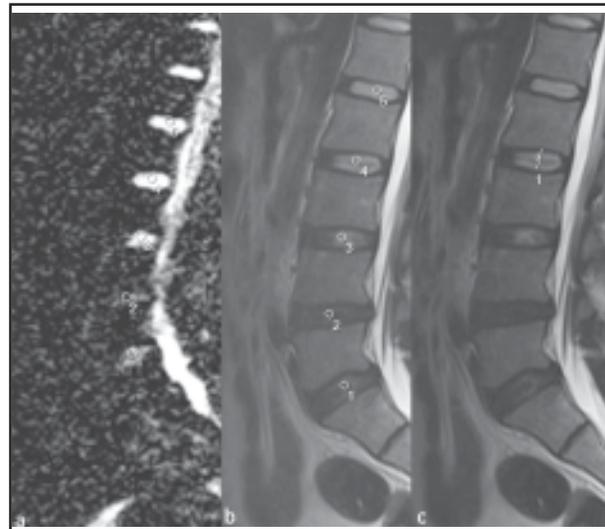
a ADC map, b and c T2-weighted fast spin-echo image of the lumbar spine of one case. ROIs for ADC measurements were placed on L1-2to L5-S1 discs. Line on the T2-weighted image shows height (H) and ROIs indicate measurements for T2 signal intensities.
